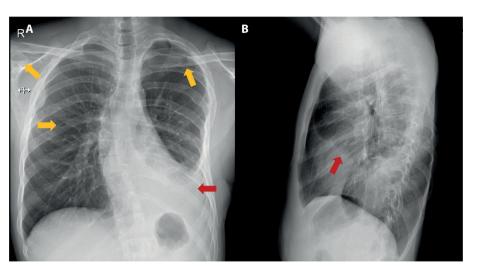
Chest X-ray. A. Posteroanterior projection. B. Lateral projection. Image corresponding to the latest medical check-up showing moderate residual free pleural effusion in the left lung field (red arrow), with fewer lytic lesions observed compared to the onset of the disease (yellow arrow).
